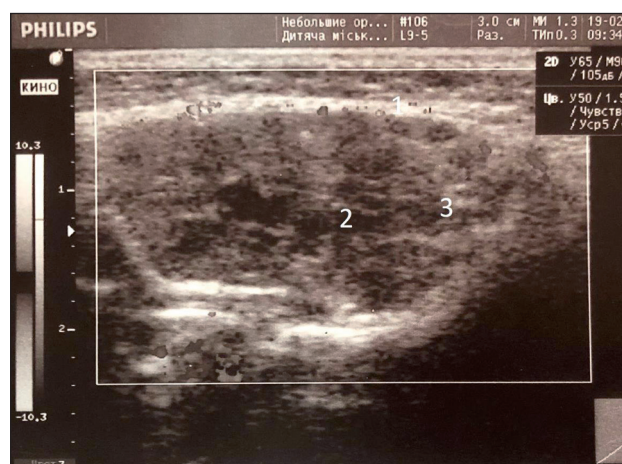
Ultrasound image of the left parotid gland. The echo-compacted capsule (1) is defined, in parenchyma existence of moderate quantity of sialectases of various form in the sizes from 3 to 4 mm (2) is traced, among them single hyperechogenic sites (3)
